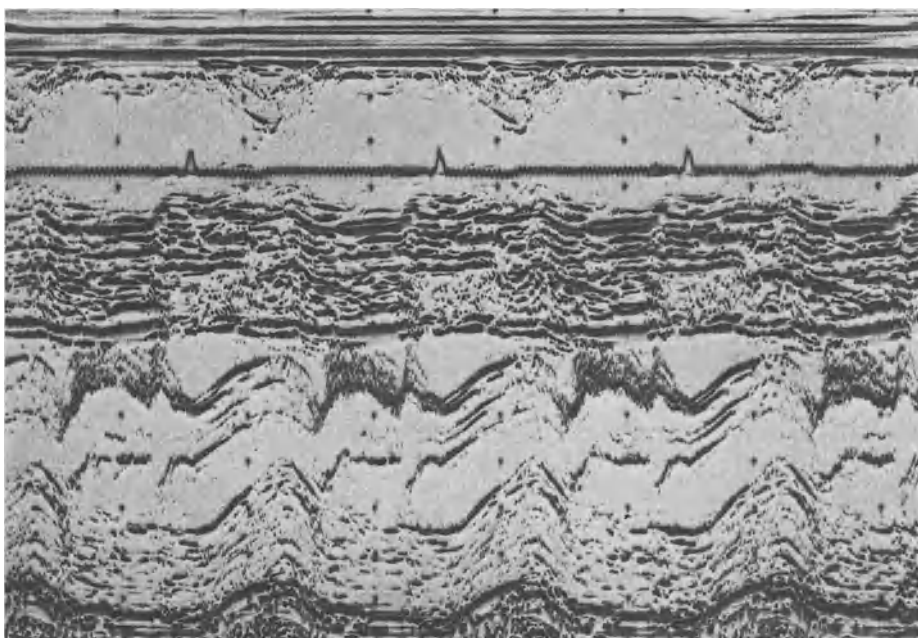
Echocardiogram of a patient with combined aortic valve disease and dynamic subvalvular outflow obstruction. The high-frequency flutter of the anterior mitral valve leaflet is indicative of aortic regurgitation. Note the asymmetrical septal hypertrophy in relation to the hypertrophied left ventricular posterior wall
